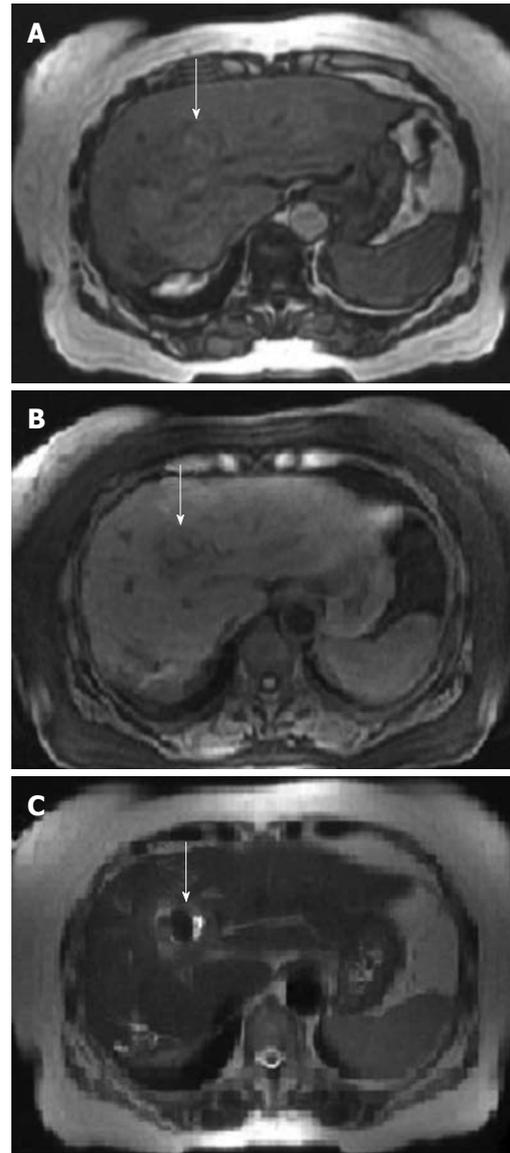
Magnetic resonance imaging scans of the abdomen revealed that hepatic artery pseudoaneurysm was replaced by thrombus formation (white arrows) in the left lateral segment in-phase (A) and out-of-phase (B) T1-weighted images and T2-weighted image (C).
